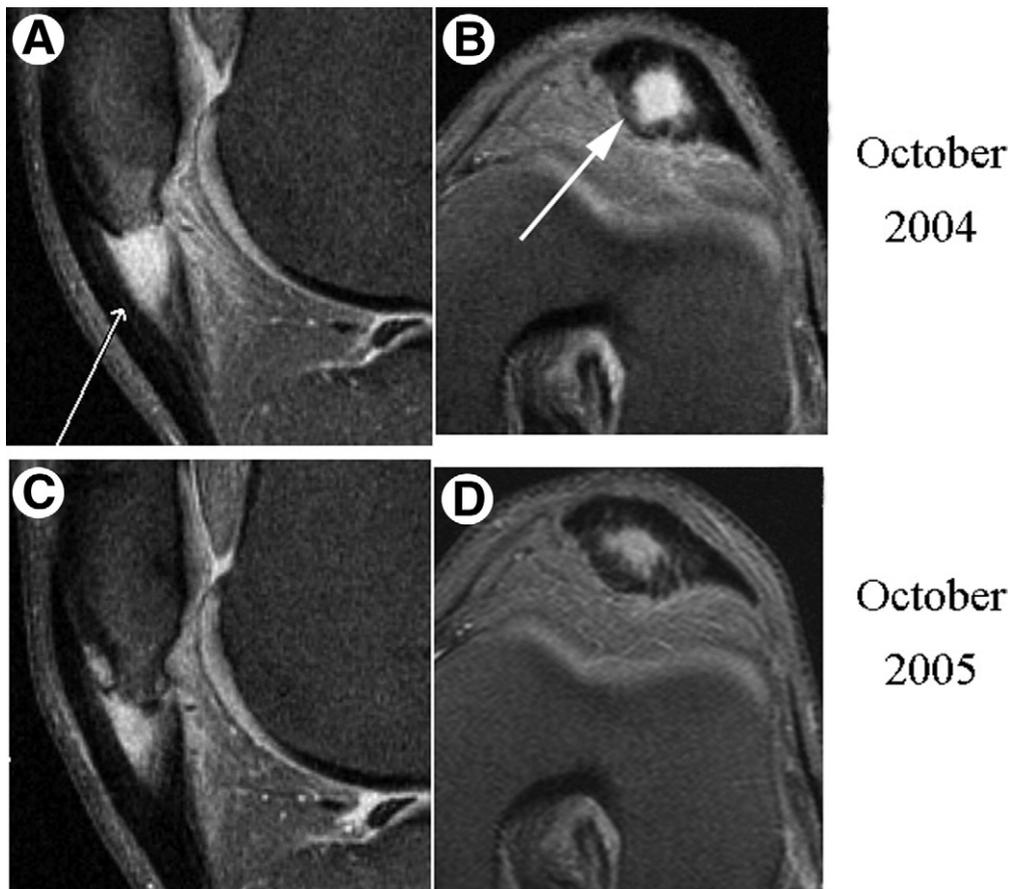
Proton density, fat saturation MRI of the knee (pre- and postprolotherapy). Top row, October 2004; bottom row, October 2005. (A and C) Sagittal views of left knee. The thin arrow (originally added by the interpreting radiologist) indicates a high signal in the deep, midportion of the patellar tendon consistent with partial tear. Note the reactive edema in the inferior pole of the patella (A) in 2004. Postprolotherapy, the edema is resolved and a subperiosteal cyst is noted (C). Images on the right (B, D) are axial views of the left knee through the patellar tendon; the large arrow in B points to the region of the thickened, abnormal tendon with high-signal intensity just distal to the patellar enthesis, indicating a partial patellar tendon tear. The postprolotherapy (D) shows new tendon growth and partial repair of the tear.
